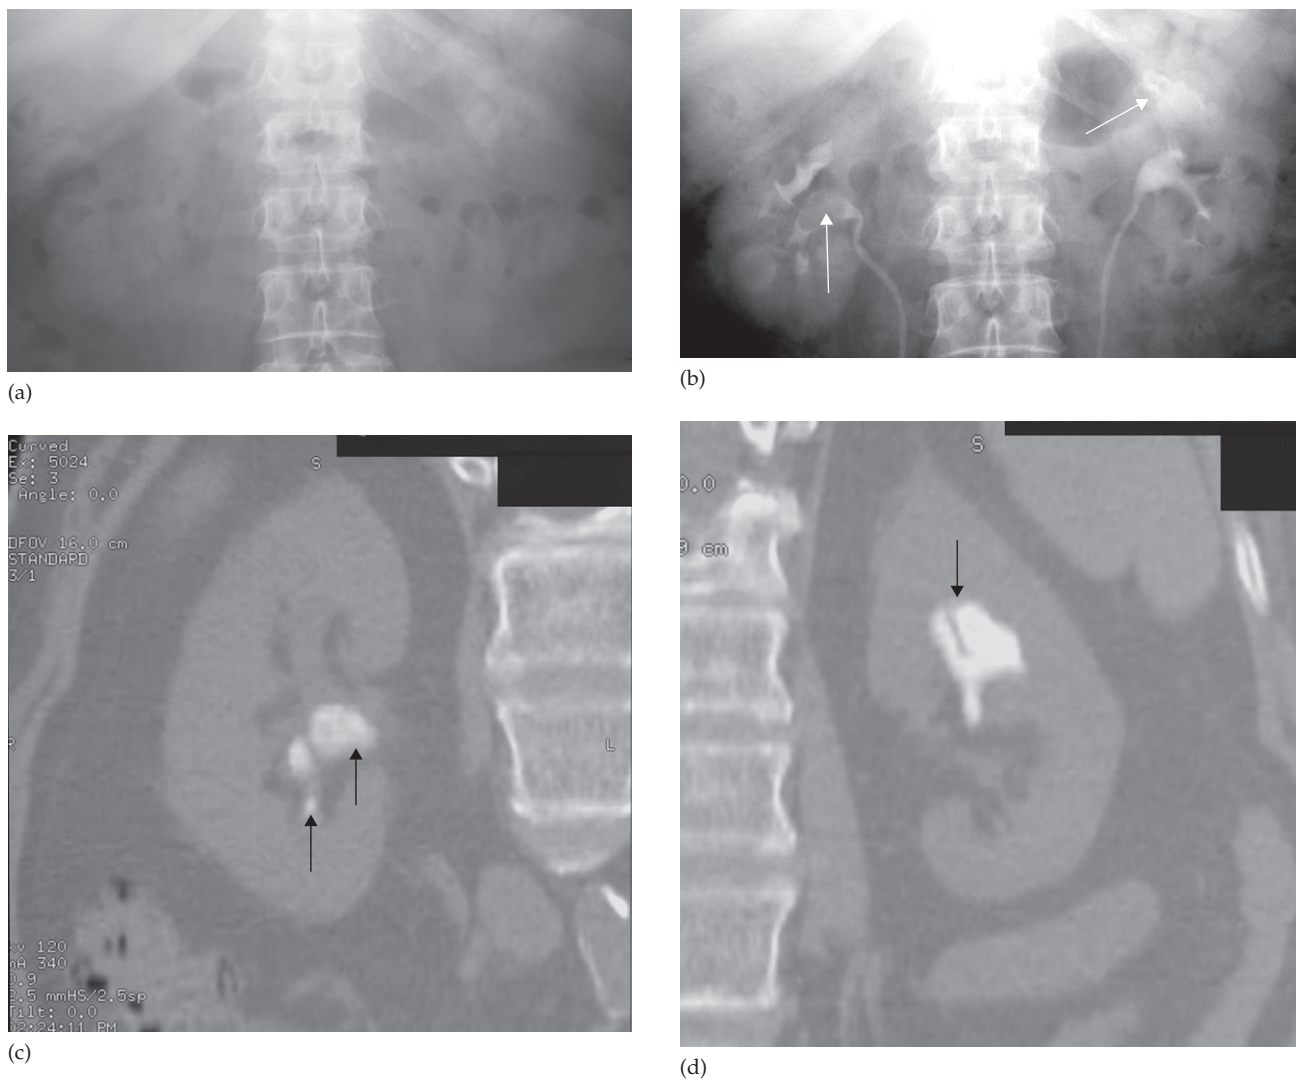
(a) IVU control film. Renal stones are not visible on the right and are very poorly visualized on the left. (b) IVU following intravenous contrast. Filling defects are seen in the right lower calix and pelvis and in the left upper pole calices (arrows). (c, d) CT of the kidneys in the same patient with no contrast medium, reformatted in the coronal plane, demonstrating the renal stones in both the right (c) and left (d) kidneys (arrows).
